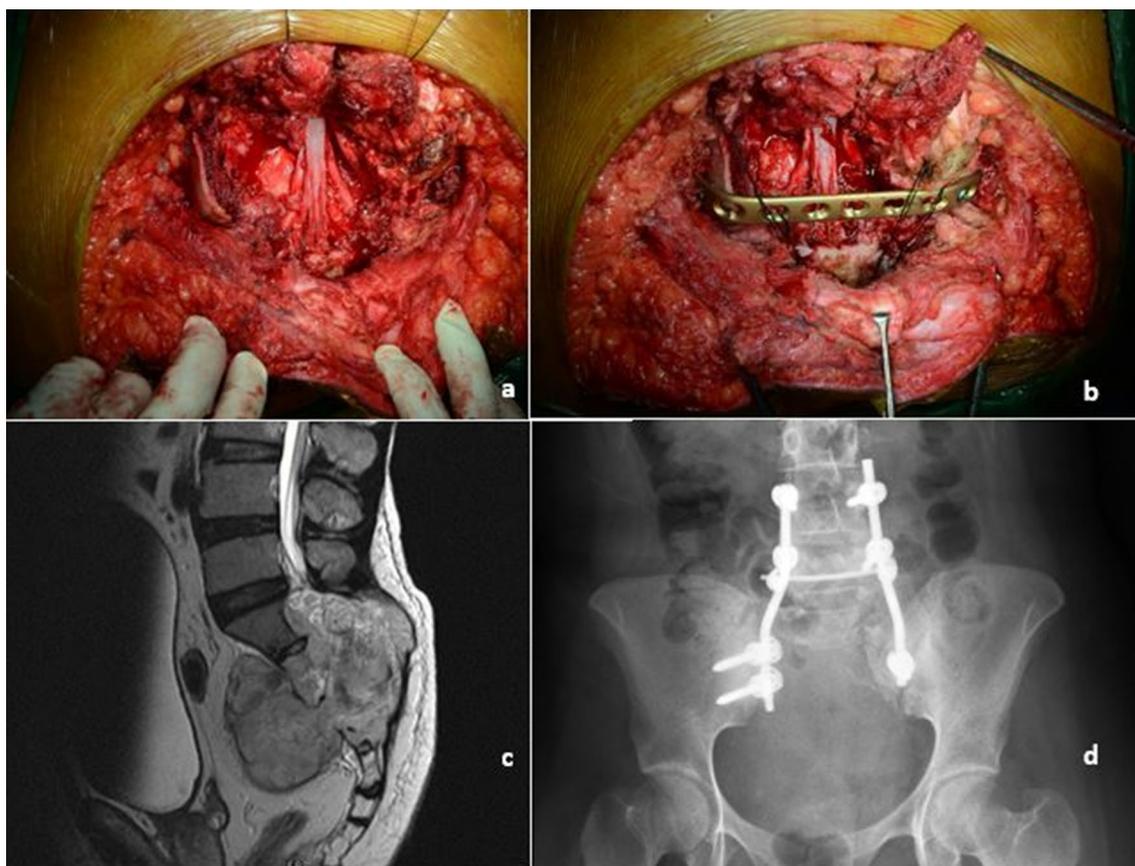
Intraoperative photographs showing a bilateral ileal osteotomy for removal of tumour involving S1. b Spino-pelvic reconstruction was done with a contoured plate. c T2-weighted MRI showing
